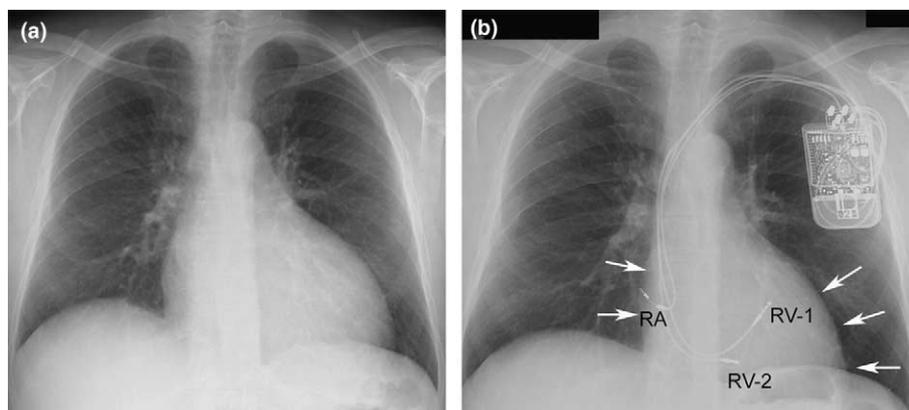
(a) Chest X-Ray of a patient with NYHA class-III heart failure one day before implantation of the system for cardiac contractility modulation (CCM). (b) Substantial improvement of cardiothoracic ratio after 8 weeks of CCM therapy (arrows); two right ventricular septal leads (RV-1 and RV-2) for delivery of CCM stimulation, one right atrial (RA) lead for sensing atrial activity.
